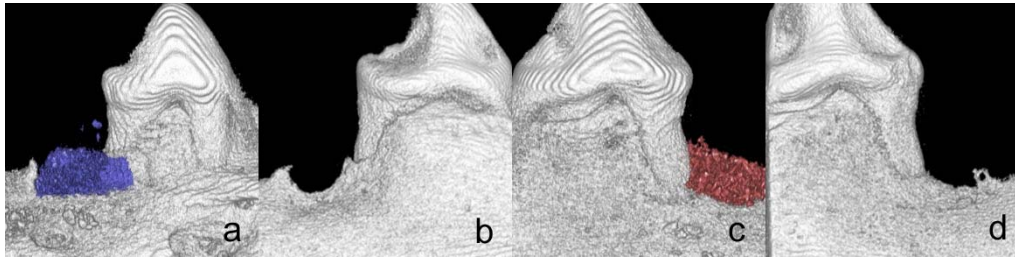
Micro CT view. HA remained overtopped compared to the height of contacting alveolar bone with unchanged shape (a). Bio-oss collagen maintained the shape in 2 sites (c) out of 5, but in the other 3 sites most of the grafts were lost and bone formation was minimal. (b) & (d) is the view of control sites.
